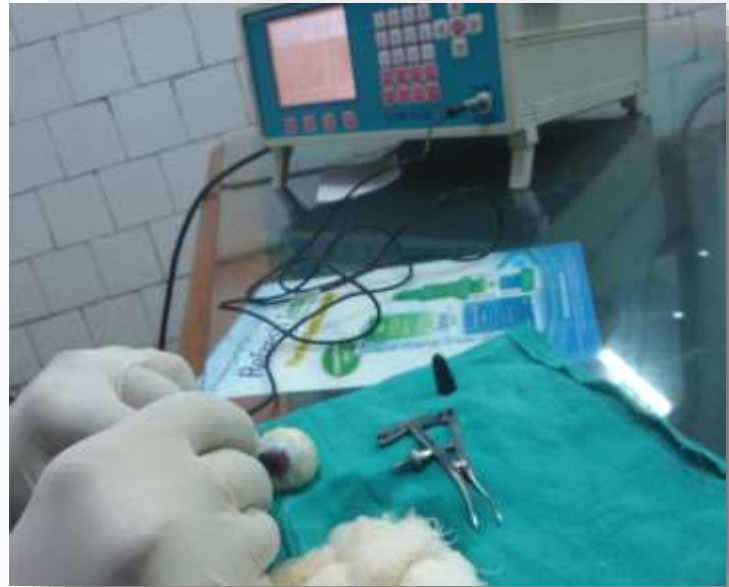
Axial Length measurement by Ultrasonic A Scan
